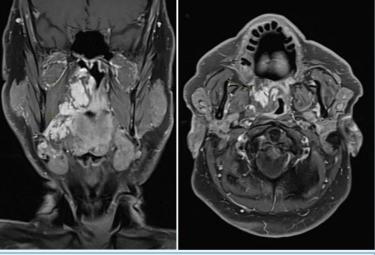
displays a T2 FLAIR MRI scan.
